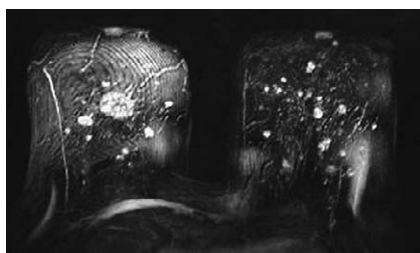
Axial maximum-intensity projection (MIP) shows synchronous invasive lobular cancer (ILC). The MRI was performed for staging multifocal right ILC (luminal A, ER 8%, PR 44%, Ki67 15%, G2 and luminal B; HER-2 negative, G2, ER 19%, PR 18%, Ki67 15%). In the axilla 24/44 lymph nodes were infiltrated (N3). Additional suspicious areal of non-mass enhancements were found in the left breast. Ultrasound guided biopsy was performed and additional ILC was proven (luminal B; HER-2 negative, ER 4%, PR 2%, Ki67 11%). The initial surgical plan after MRI was changed.
